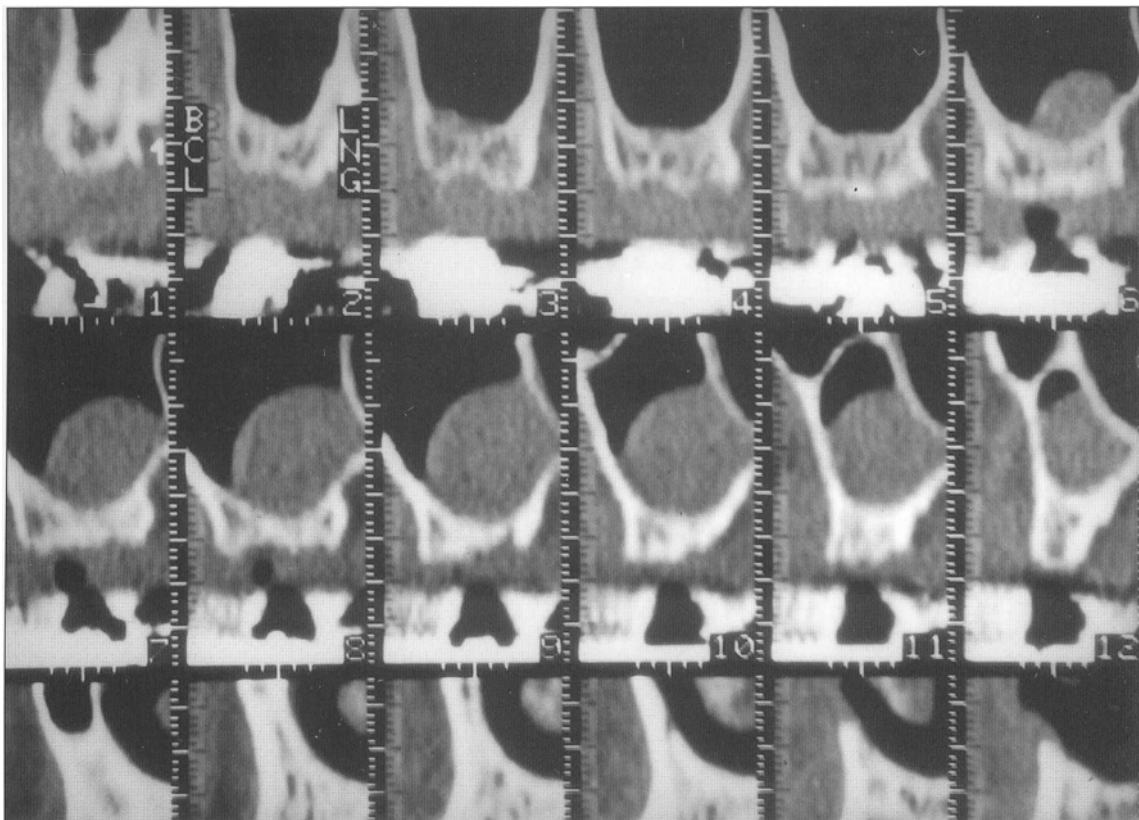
The presence of a mucocoele as seen on computerized tomographic (CT) scan. This pathologic entity should be treated prior to sinus augmentation.
